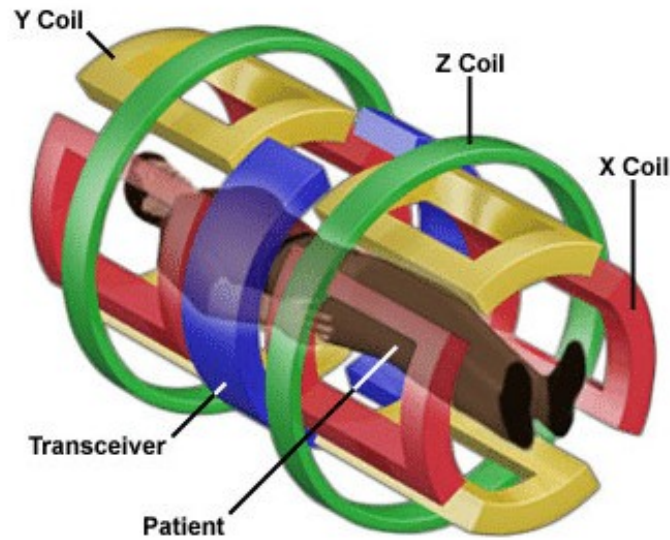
MRI scanner gradient magnets.
